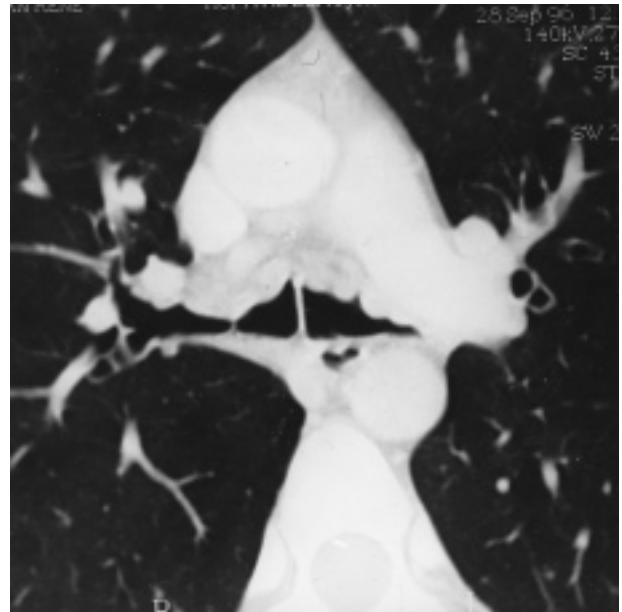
Computed tomography scan of the thorax showing nodular stenoses of the two mainstem bronchi (2 weeks after the admission).
